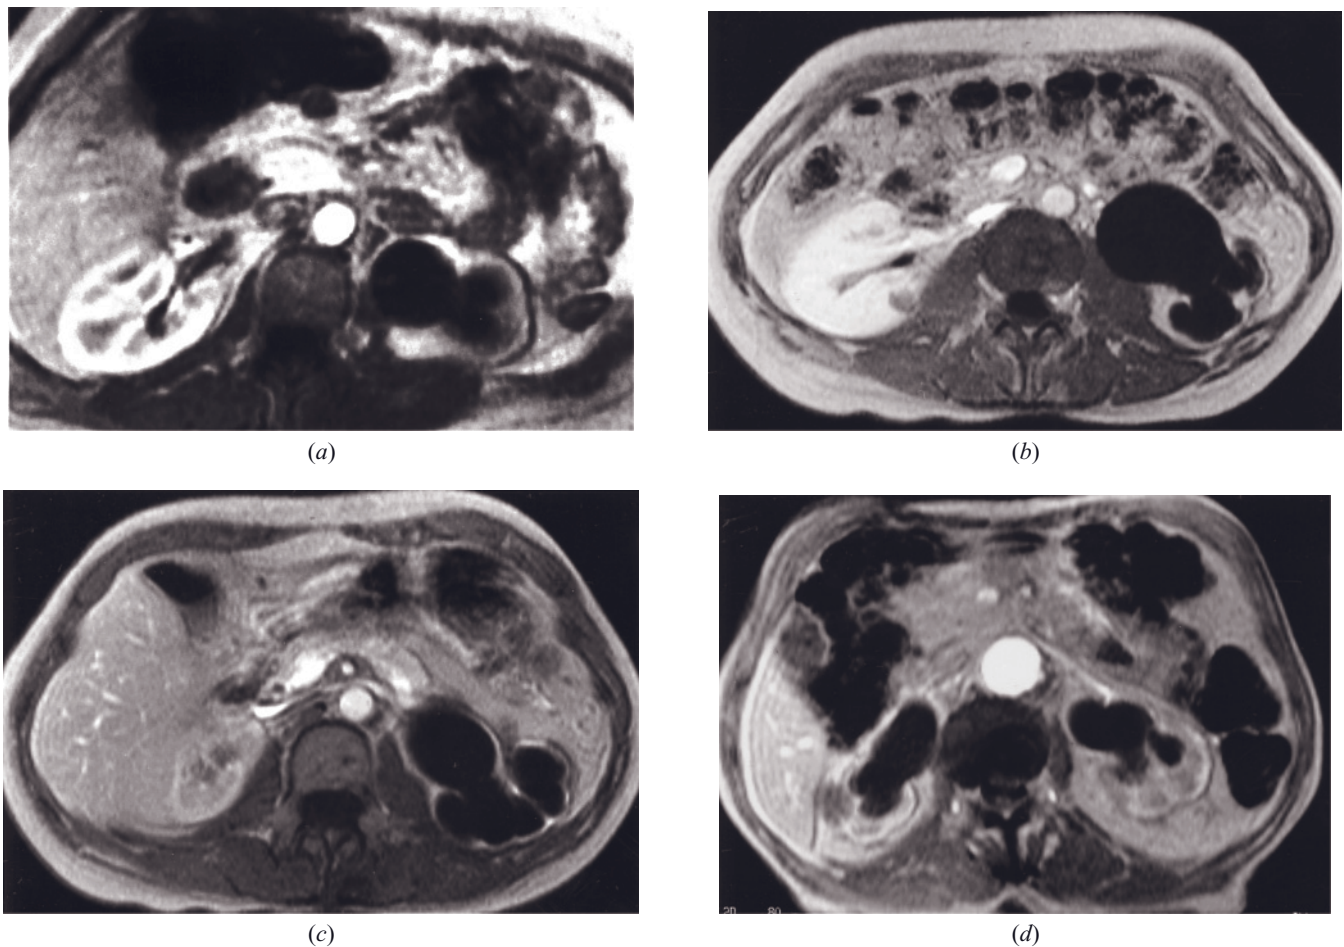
Chronic renal obstruction. T1-weighted immediate postgadolinium SGE images in 5 patients with chronic renal obstruction (a-e). In all cases of unilateral obstruction (a-c), the degree of cortical enhancement is less than that of the contralateral normal kidney. Substantial pelvicalyceal dilatation is present in all cases. Corticomedullary differentiation is diminished, and the cortex
